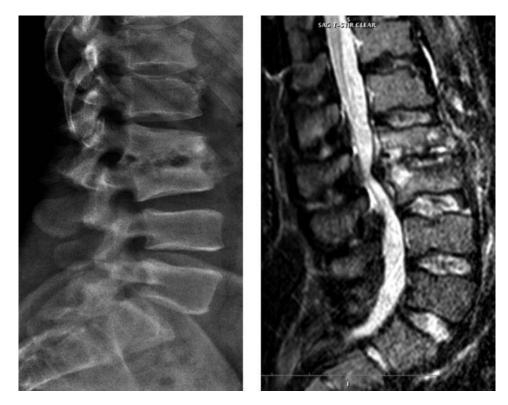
X-ray and MRI show focal L2-L3 kyphosis, erosion of L2 inferior endplate and superior L3 endplate with degeneration of the L2-L3 disc and segmental L2-L3 stenosis.
